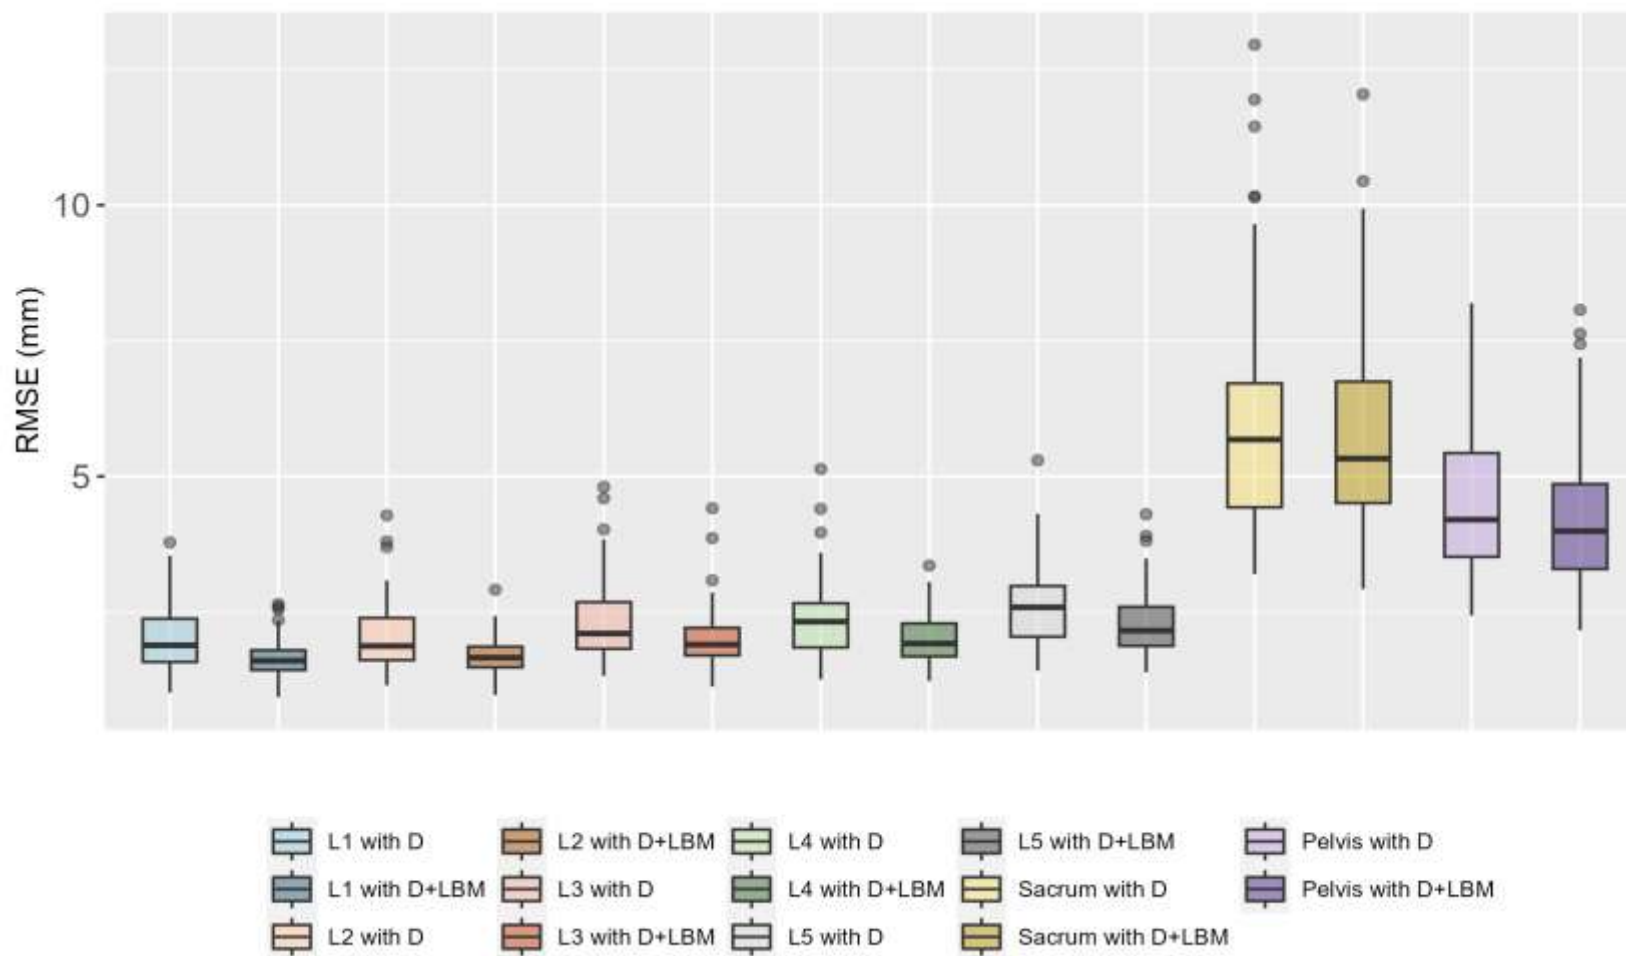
RMSE (mm) of Euclidian distances between CT reconstructed, and SSM predicted L1, L2, L3, L4, L5, pelvis and sacrum for only with demographics (D) and with demographic and linear bone measurements (D+LBM)
